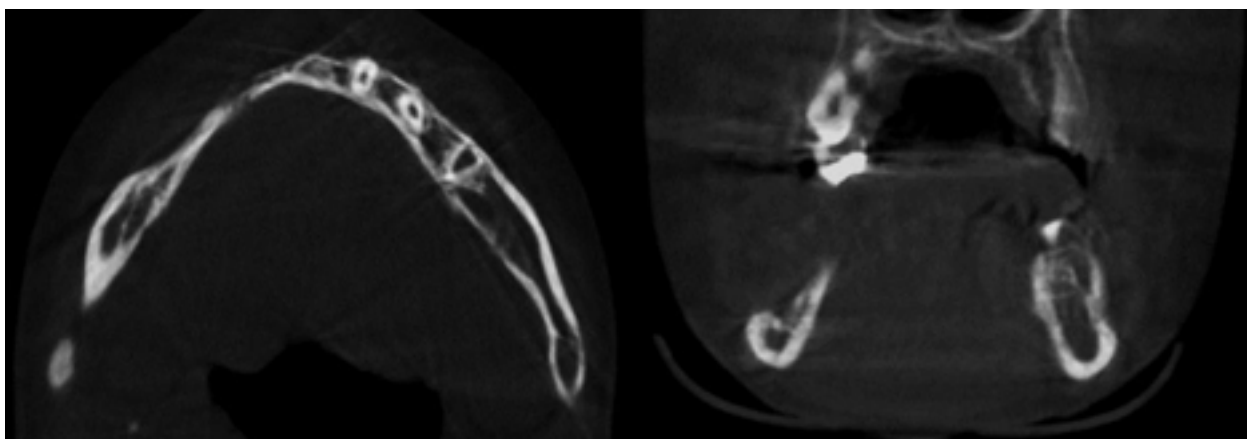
Axial and coronal CBCT slice exhibiting mandibular bone.
